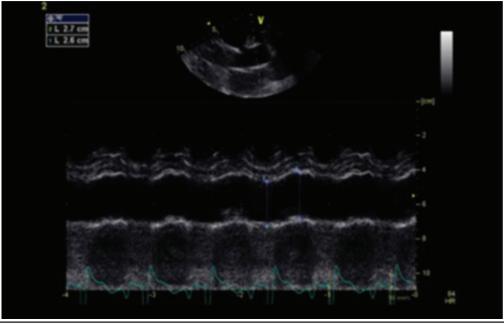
Standard Two-Dimensional and M-Mode Echocardiography Performed by GE Vivid 7 System
